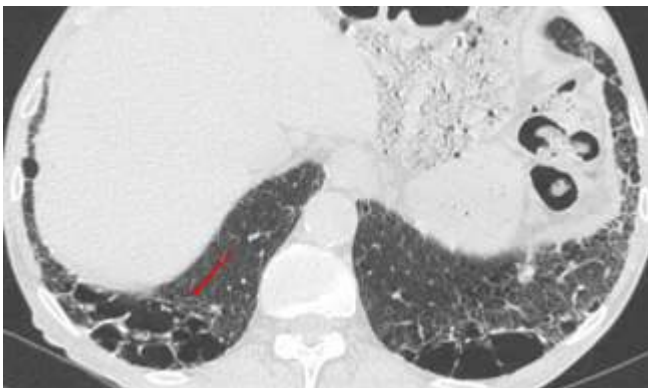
Airway expansion with fibrosis (AEF). Axial CT through the lung bases shows large cystic areas with reticular opacities, a pattern typically seen with AEF, which is a type of SRIF.
